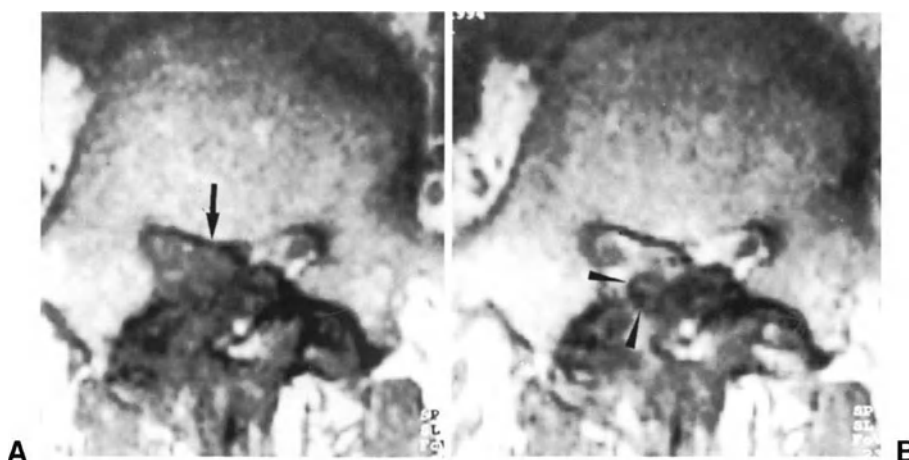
MRI scans of a patient with recurrent herniation at L4-L5 level, which developed 13 months after the removal of a herniation migrated caudally to the L4-L5 disc on the right. (A) Spin-echo T1-weighted axial image before gadolinium injection, showing tissue of uncertain origin in the epidural space (arrow) at the site of primary discectomy. (B) Spin-echo T1-weighted axial image after gadolinium, in which the abnormal tissue in the epidural space shows an increased signal intensity compared with pre-contrast image, except for a small fragment of tissue displacing the thecal sac posteriorly, (arrowheads). These images suggest the presence of an extruded disc fragment surrounded by abundant epidural scar tissue. This diagnosis was confirmed at surgery.
